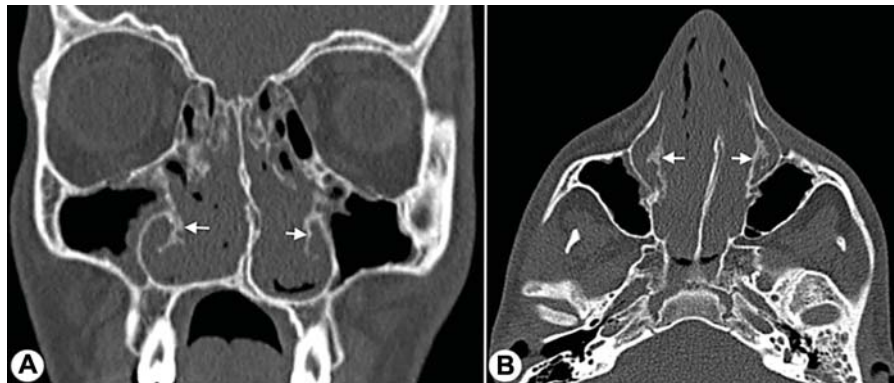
Non-contrast computed tomography (CT) scan of the paranasal sinuses: (A) coronal and (B) axial views showing bulky soft-tissue density involving the bilateral nasal cavity, the middle meatus and the anterior ethmoid region, causing expansion of the nasal cavity with lateral displacement of the lateral nasal wall. The 'fluffy' bony changes, most pronounced in the inferior turbinate bone, can be appreciated (arrows). (Patient-7)
